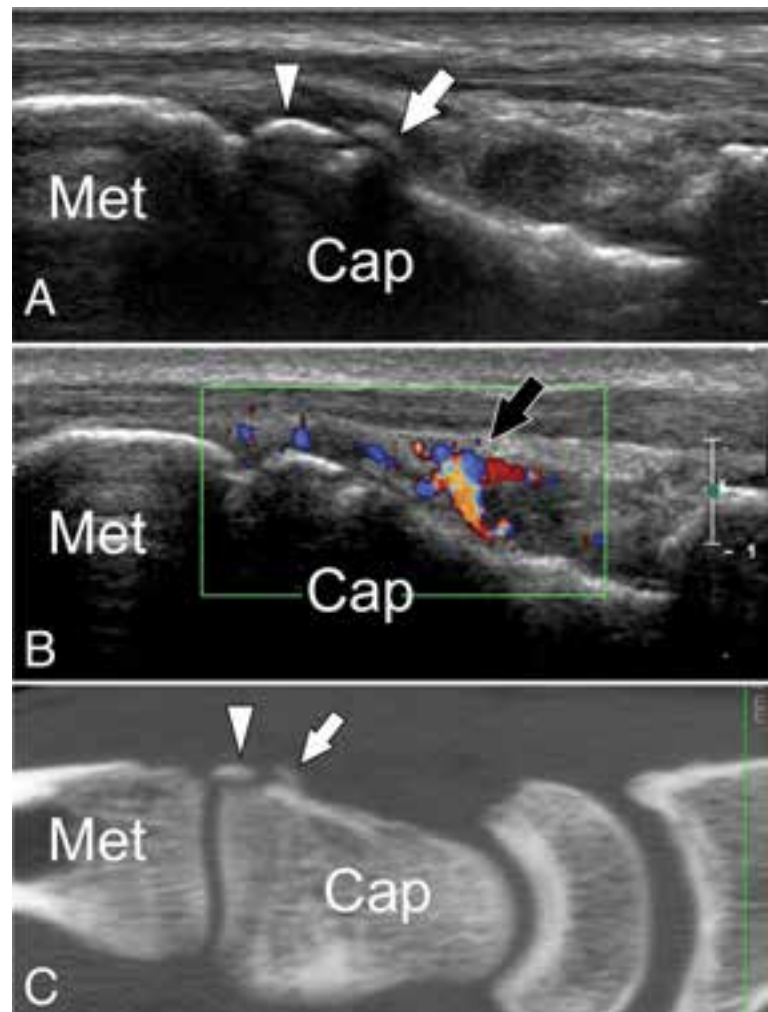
(Below): Bone trauma. Capitate fracture. (A) Sagittal US (B) and colour Doppler US obtained over the dorsal aspect of the wrist in a patient that sustained a local trauma. US was obtained to rule-out a dorsal ganglion. (C) reformatted sagittal CT image of the wrist. US images show a cortical avulsion (arrowhead) of the distal capitate (Cap) Note the adjacent calcified callus (arrow). Note how the calcified callus is less echogenic than the fragment. In (B) colour Doppler shows the hyperaemia of the periosteum and adjacent soft tissues. CT confirms the US findings. Met=first metacarpal.
